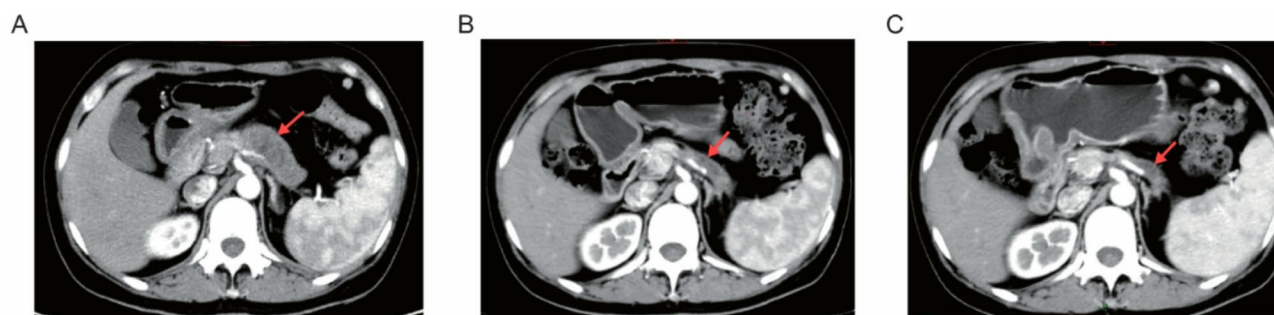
Imaging examinations of the patient before and after treatment. Axial computed tomography scans at (A) baseline; (B) after three cycles of XELOXIRI treatment; and (C) after six cycles of XELOXIRI treatment
